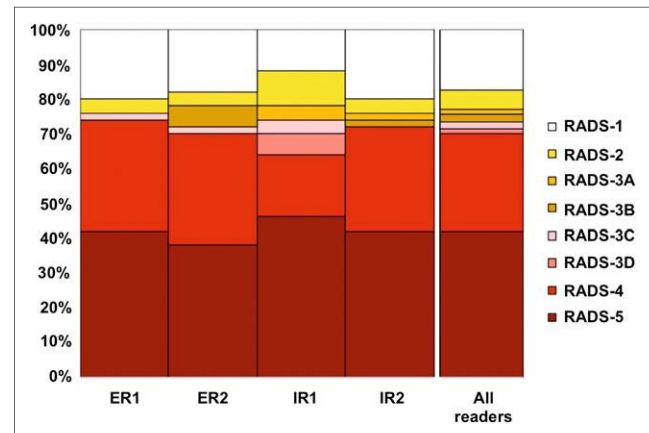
Overall-PSMA RADS scoring for all 4 readers. PSMA-RADS-1A and -1B were subsumed under PSMA-RADS-1.
